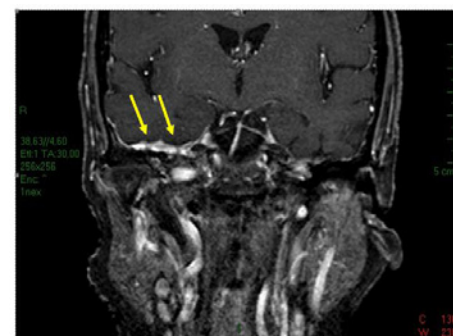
MRI: En plaque meningioma of right middle cranial fossa extending to the middle ear with intraosseous expansive lesion.
